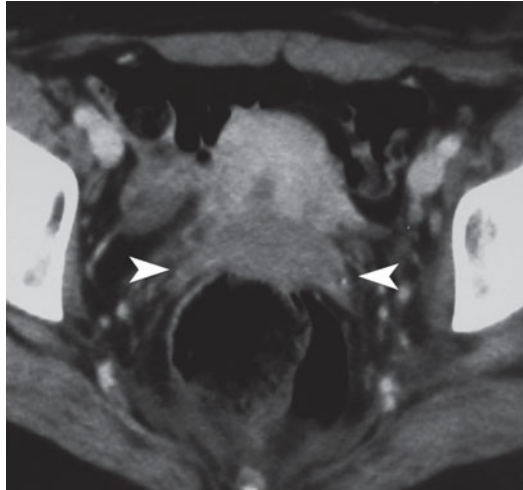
Computed tomography. Cervical cancer, stage IIB with bilateral invasion of the parametrium identifiable by the solid tissue with irregular margins in the pericervical adipose tissue (*arrowheads*)
